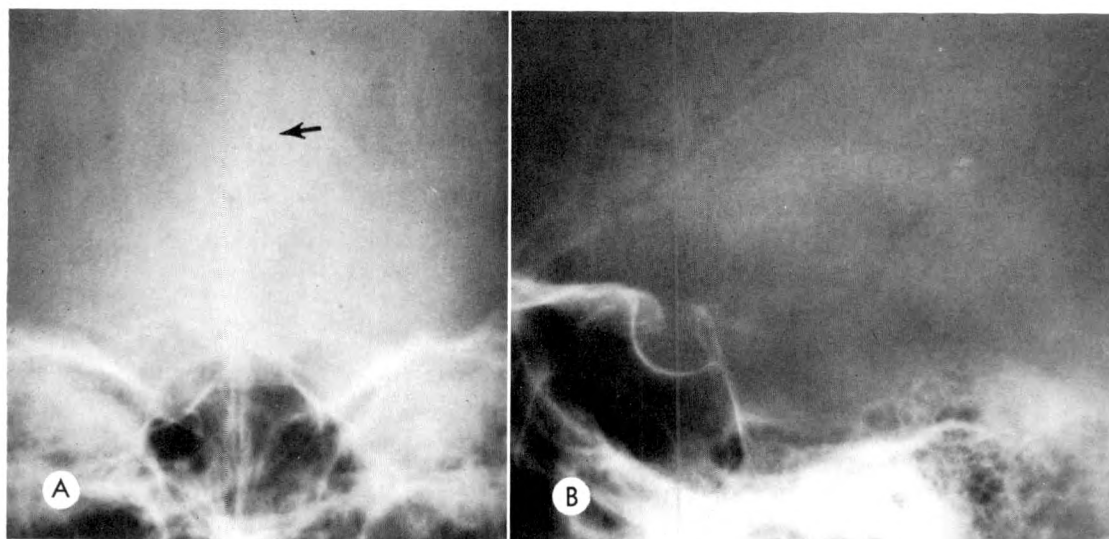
Habenular calcification without visible pineal calcification shown on both (A) frontal and (B) lateral skull roentgenograms.
